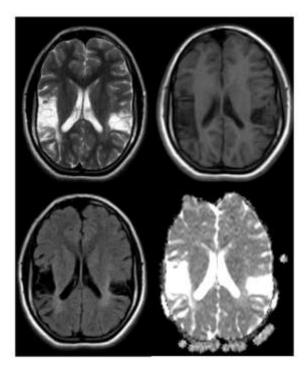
MRI Brain revealed peri insular temporal gliosis
